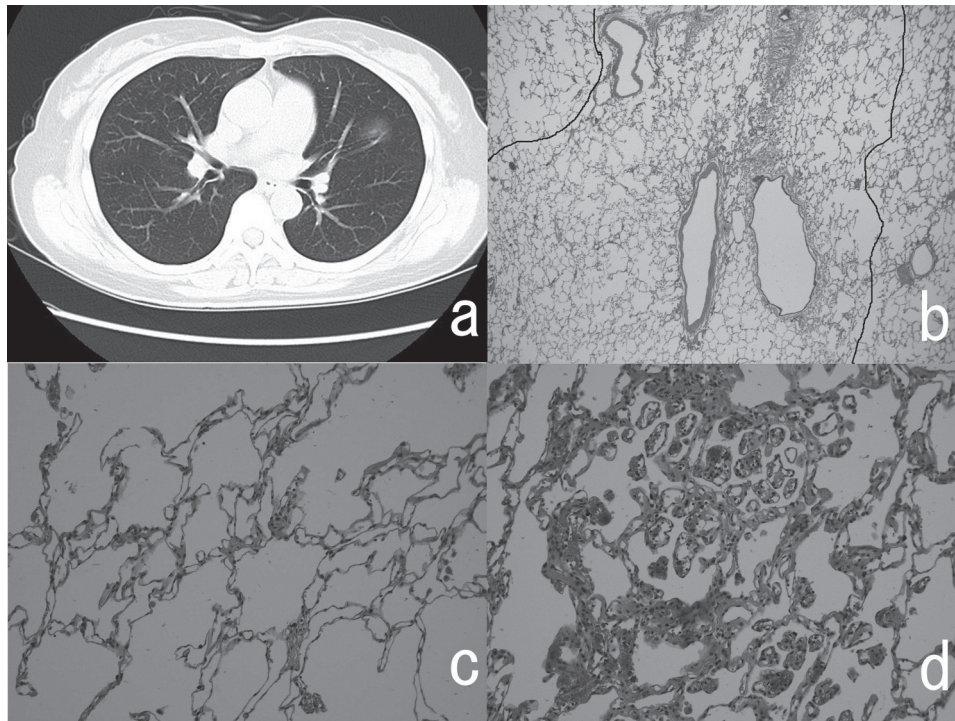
(a) Chest computed tomography (CT) showing a pure ground-glass opacity (GGO) lesion measuring 20 mm in diameter in the left S4 near the boundary between S⁴ and S¹⁺². (b, c) The lesion shows thickening of alveolar septa caused by the proliferation of capillary vessels without cytological atypia. (d) A thickened alveolar wall and partial glomerular-like change are shown.
